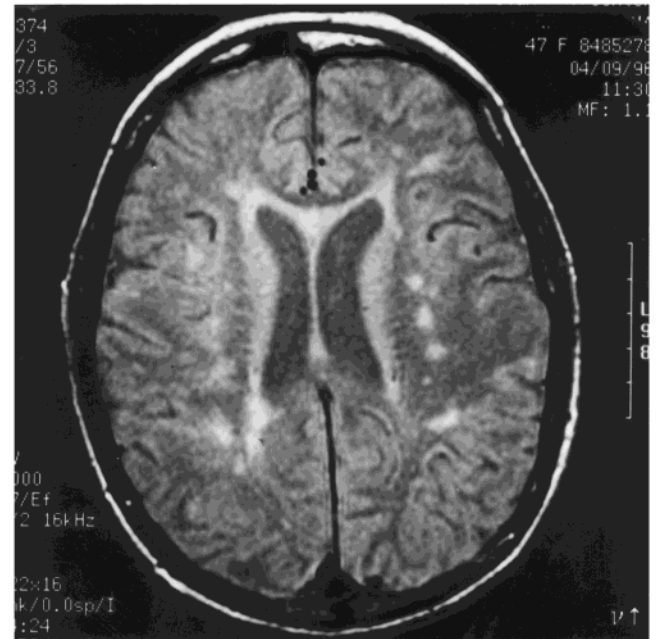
Axial T-2 weighted MRI 12 months following BMT showing no change in multiple periventricular white matter lesions (TR 2000, TE 17). No new lesions are seen.
